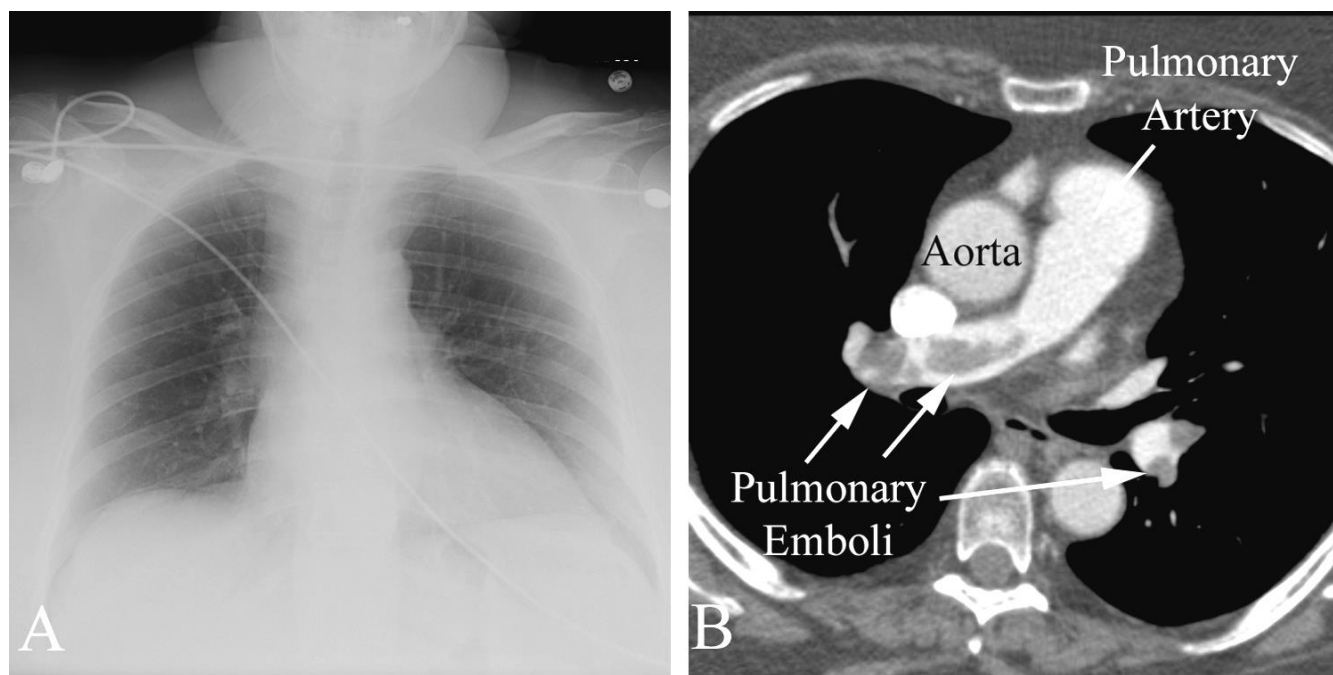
CT examination demonstrating pulmonary embolism in a 74 year old woman with acute onset of shortness of breath. A. Portable chest plain film examination was normal, as is often the case with pulmonary embolism. B. Chest CT examination demonstrates multiple filling defects within the pulmonary arteries, diagnostic of pulmonary embolism.
